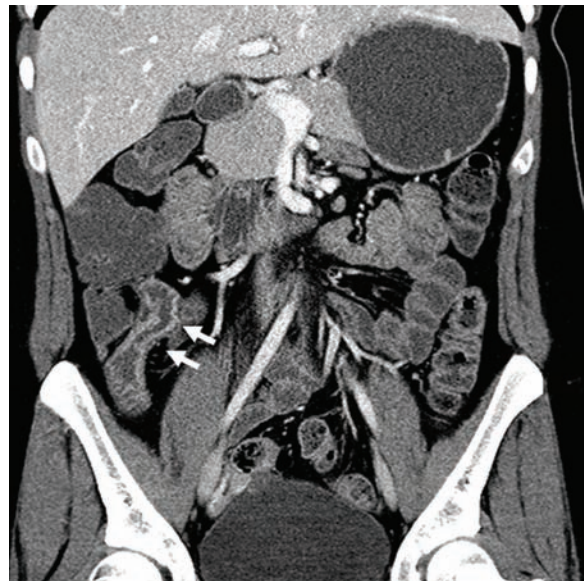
Coronal computed tomographic enterography showing distal ileal hyperenhancement and wall thickening (arrows) of active inflammatory Crohn's disease.
